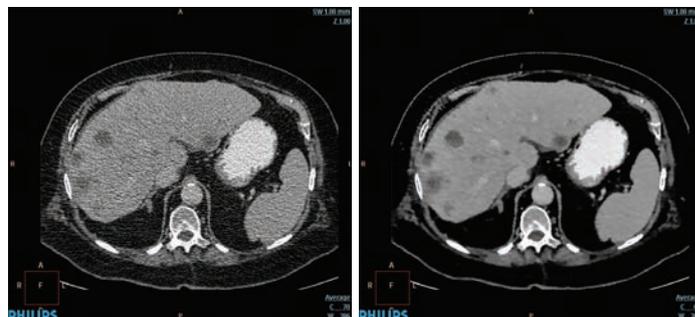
Abdominal CT images acquired with 3D modulation and an increased DRI for the liver. These techniques were used in conjunction with Iterative Model Reconstruction (IMR) (right) shown in comparison with standard reconstruction (left).
